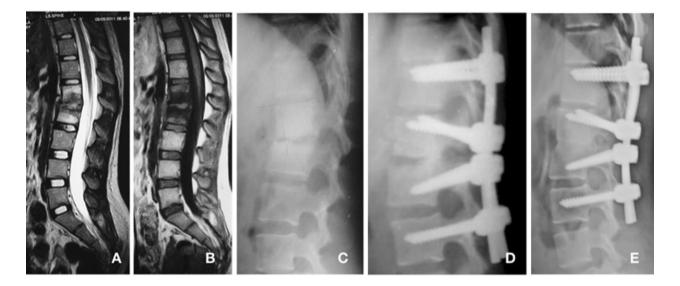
T2-weighted MRI (a) showing spondylodiscitis of L1–L2 vertebra with involvement of intervening disk and T1-weighted MRI (b) showing bone marrow edema of the involved vertebral bodies. Plain lateral radiograph (c) shows collapse of L1–L2 disk space with minimal end plate erosions and minimal localized kyphosis. Postoperative
